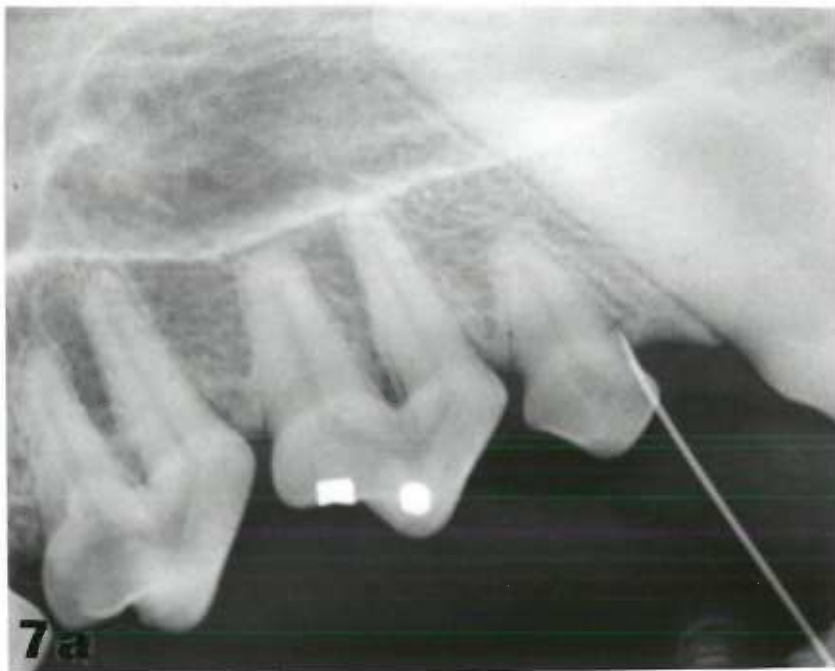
Radiographs showing needle placement for the PDL injection technique.
